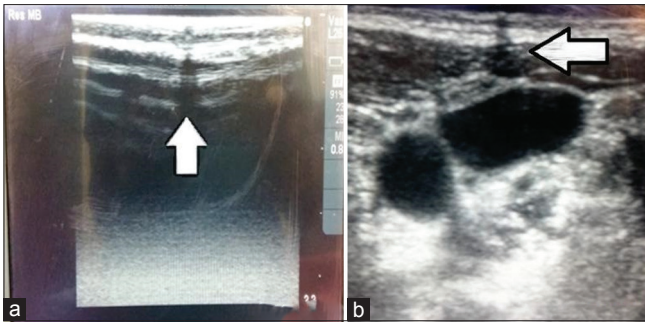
(a) Acoustic shadow of barium wire on ultrasound screen, pointed by arrow head. (b) Alignment of acoustic shadow of barium wire and right internal jugular vein just below it in the centre of screen
